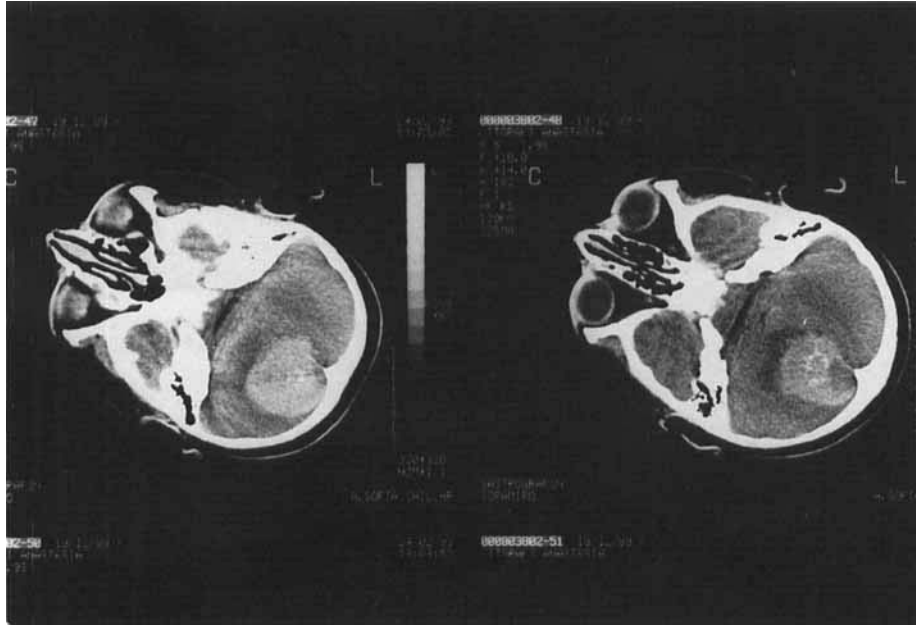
Two views of CT scan of the brain. There is a large calcifying tumor within the right cerebellar hemisphere with surrounding edema.
